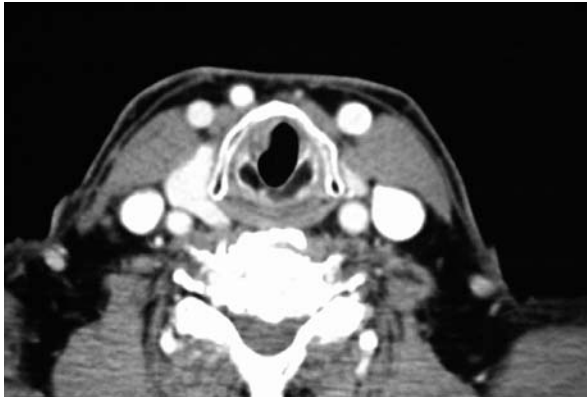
CT scan shows tumour involving right vocal fold.
